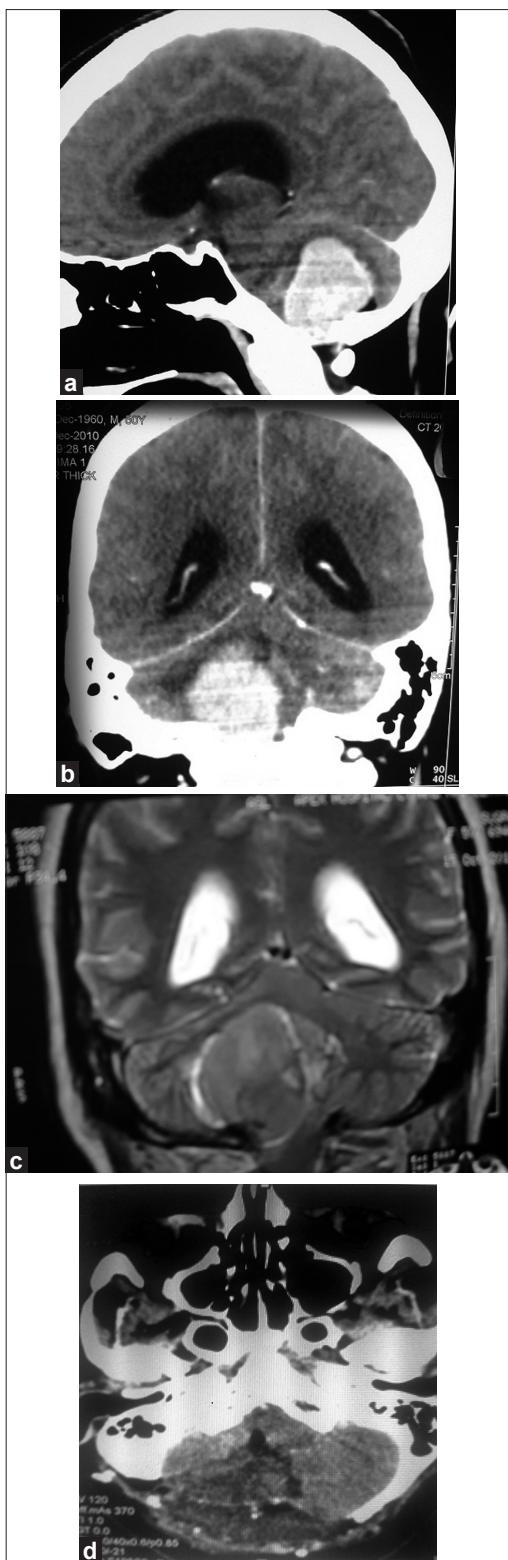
Dorsal foramen magnum meningioma with post op CT scan s/o suboccipital craniectomy defect with gross total excision
